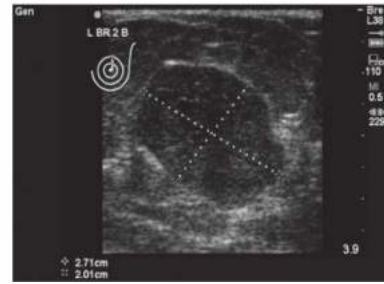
• Ultrasound of fibroadenoma prior to treatment. Size, position, and two orthogonal views are taken.
